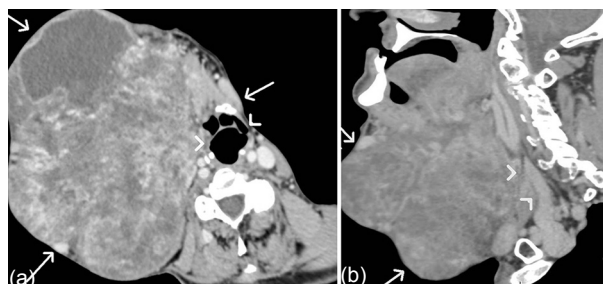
(a) Axial post-contrast computed tomography scans showing heterogeneous, lobulated tumoural mass (arrows) with displacement of the airway (arrowheads). (b) Sagittal post-contrast computed tomography scans showing tumoural mass (arrows) with compression of internal jugular vein (arrowheads).
